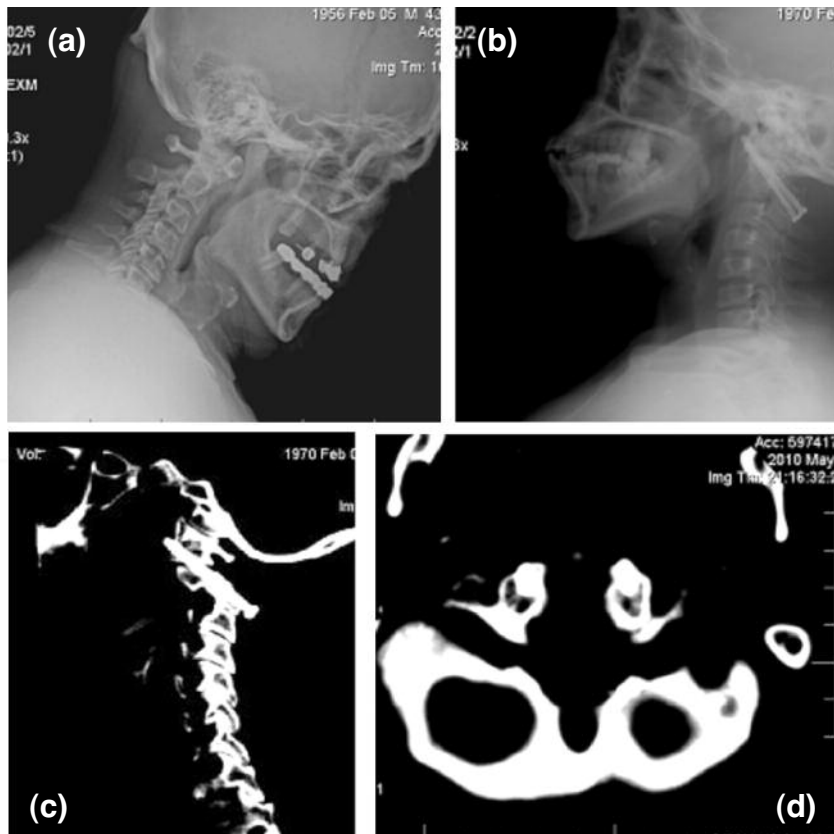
A 44-year-old women had atlantoaxial instability with os odontoideum. (a) Lateral radiograph showed os odontoideum and atlas anterior displacement. (b) Sagittal CT showed, TAS fixation and cancellous grafts could be recognized on radiograph 1 year after operation. (c) Sagittal CT showed transarticular screw and normal anatomic curvature (d) Axial CT showed bilatereal screws into the lateral mass of C1. E, Bilateral transarticular screws are showed by Coronal cervical CT.
